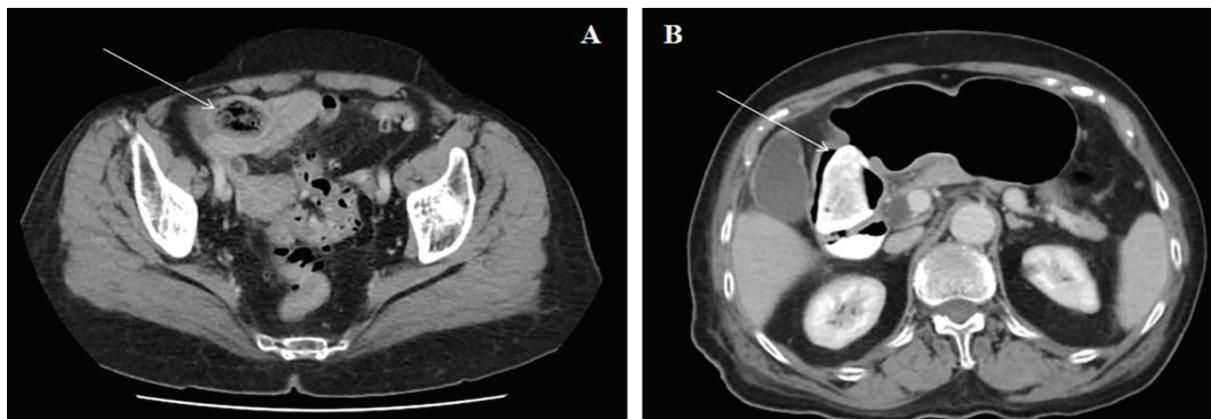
The abdominal CT scan that was performed with orally administered iodinated contrast medium. A) Intestinal obstruction due to an ileal phytobezoar (white arrow). B) A gastric phytobezoar impacted in the duodenal bulb (white arrow)
